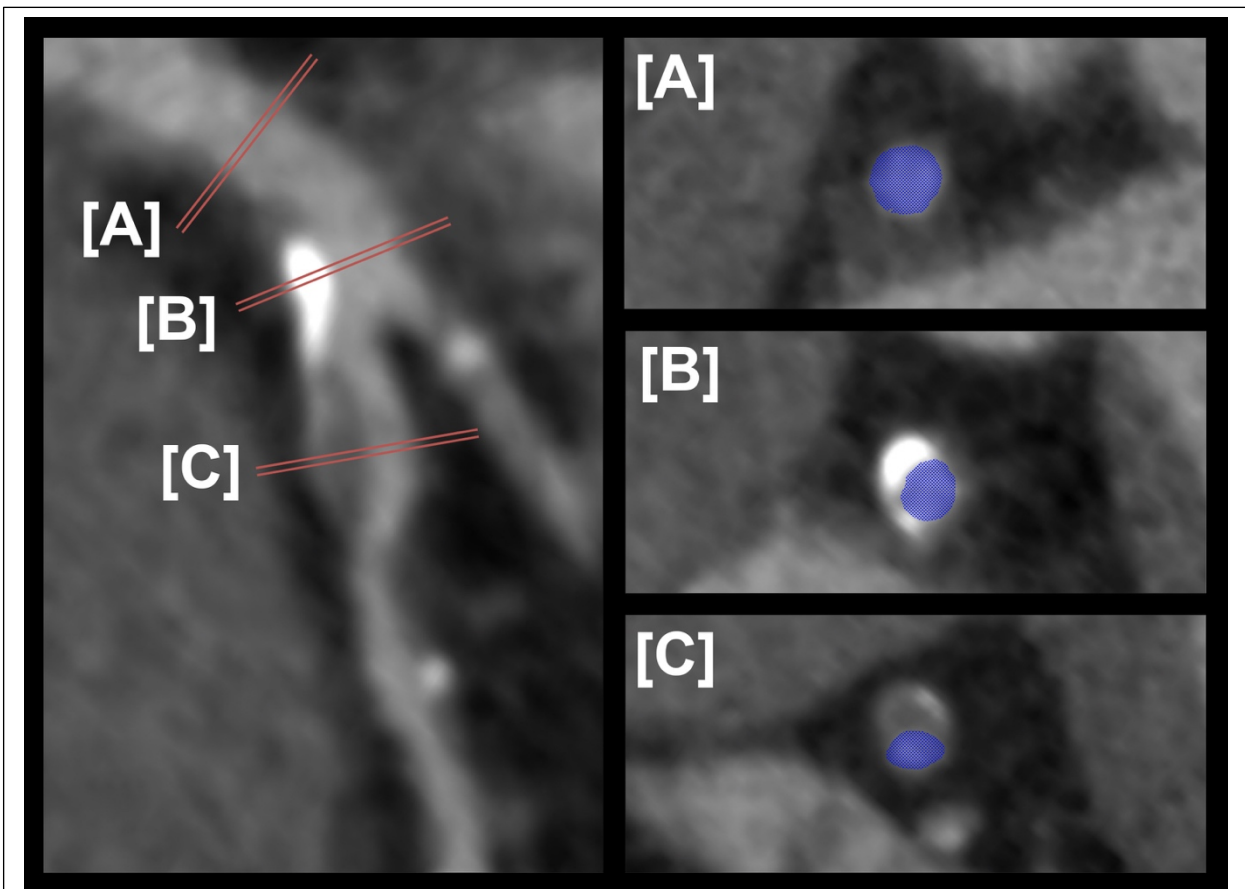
CT coronary angiogram of diseased coronary artery
